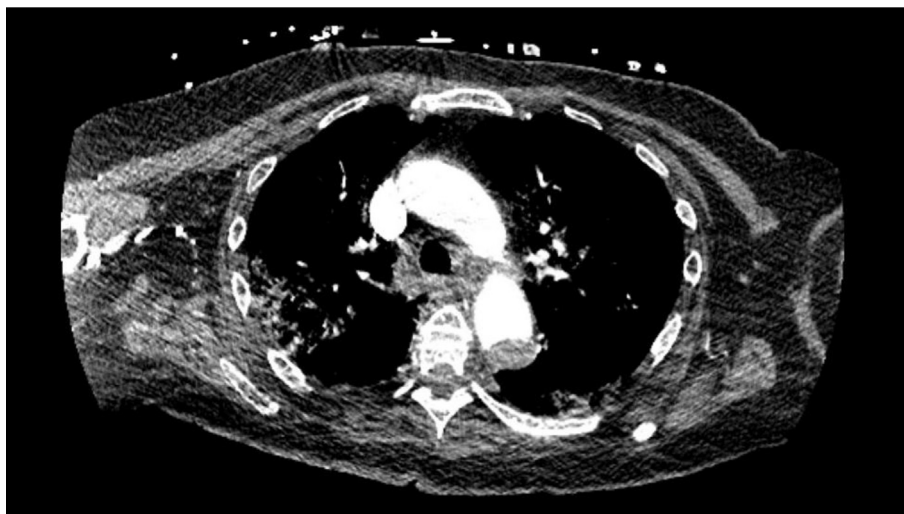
Axial Section of the chest CT showing Aortic thrombus.
